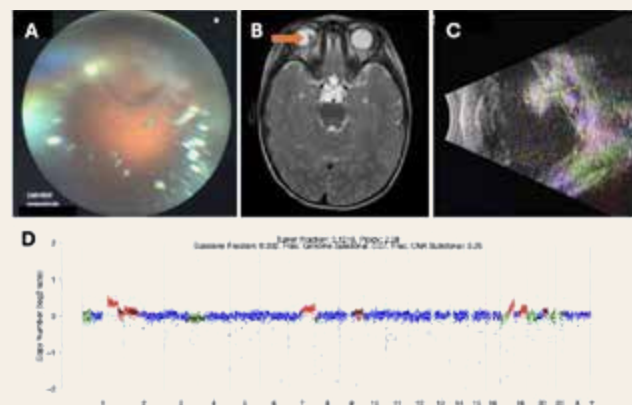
(A) Fundus photography demonstrating stalk-like intraocular tumor with vitreous seeding. (B) MRI demonstrating diffusely nodular hypercellular tumor along posterior aspect of the right globe with components appearing to extend toward the lens, possibly along Cloquet’s canal. (C) B-scan US of the lesion measuring 7.96 mm x 14.03 mm. (D) Corresponding AH genomic profile OD showing pathogenic SCNAs consistent with malignancy.
